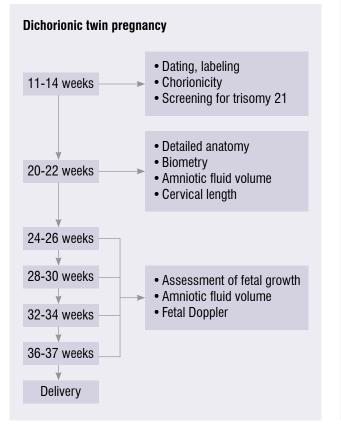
Ultrasound monitoring pathway in uncomplicated dichorionic twin pregnancy $^{7]} \label{eq:product}$
